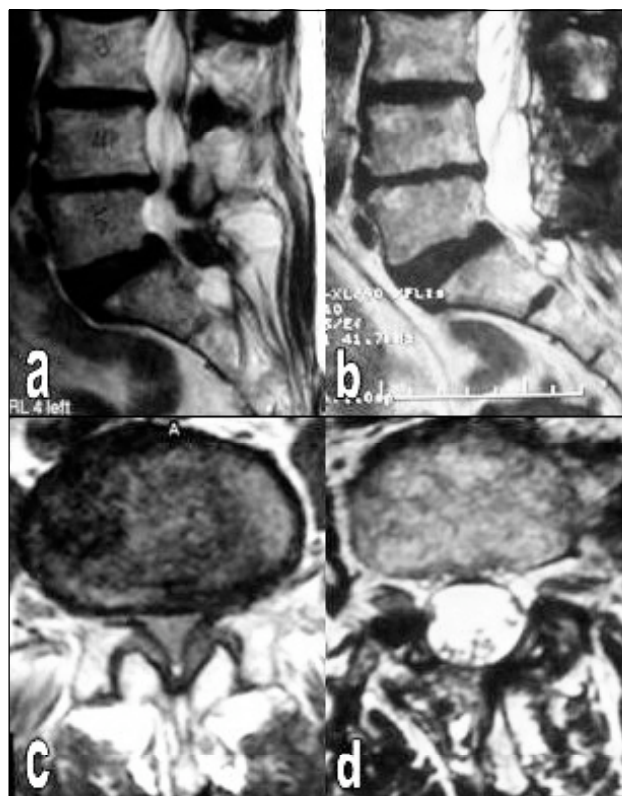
Preoperative and postoperative T2-weighted MR images obtained in a patient undergoing four levels decompression. Preoperative (a) and postoperative (b) sagittal images, and pre- (c) and postoperative (d) axial images.
